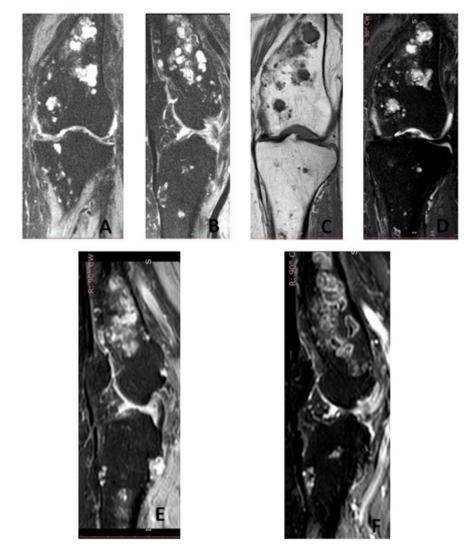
numerous lobulated focal lesions, some of which converge in specific areas and exhibit internal septations. The majority of these lesions are confined within the bone marrow. These lesions display low signal intensity on T1-weighted sequences (Figure 2C, 2E), high signal intensity on T2 – PD weighted sequences (Figure 2A, 2B, 2D), and demonstrate ring-like and septal enhancement following the intravenous administration of a paramagnetic contrast agent (Figure 2F). There were no signs of malignant transformation, such as soft tissue extension or cortical breach.
